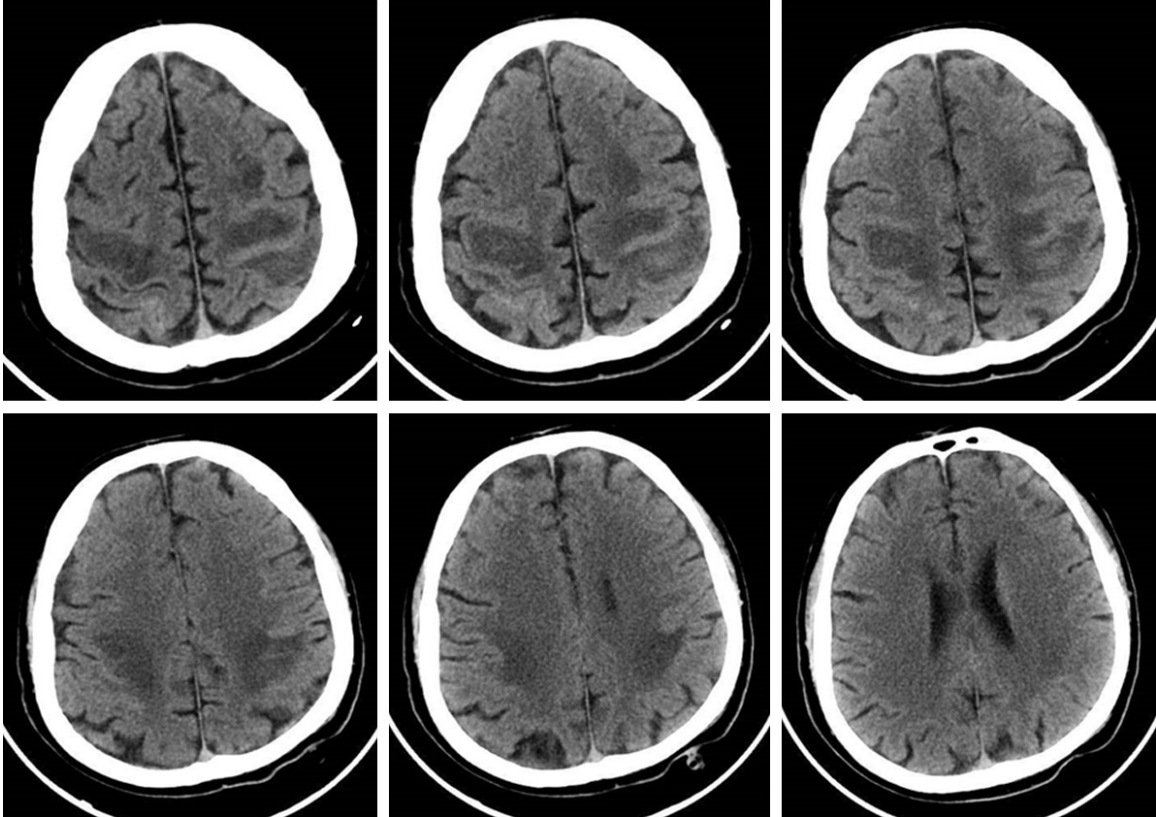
A brain CT scan showed that the area and density of hemorrhage in the bilateral frontal and parietal lobes were significantly reduced, the edema zone around some lesions was increased, and the subarachnoid hemorrhage was reduced.
